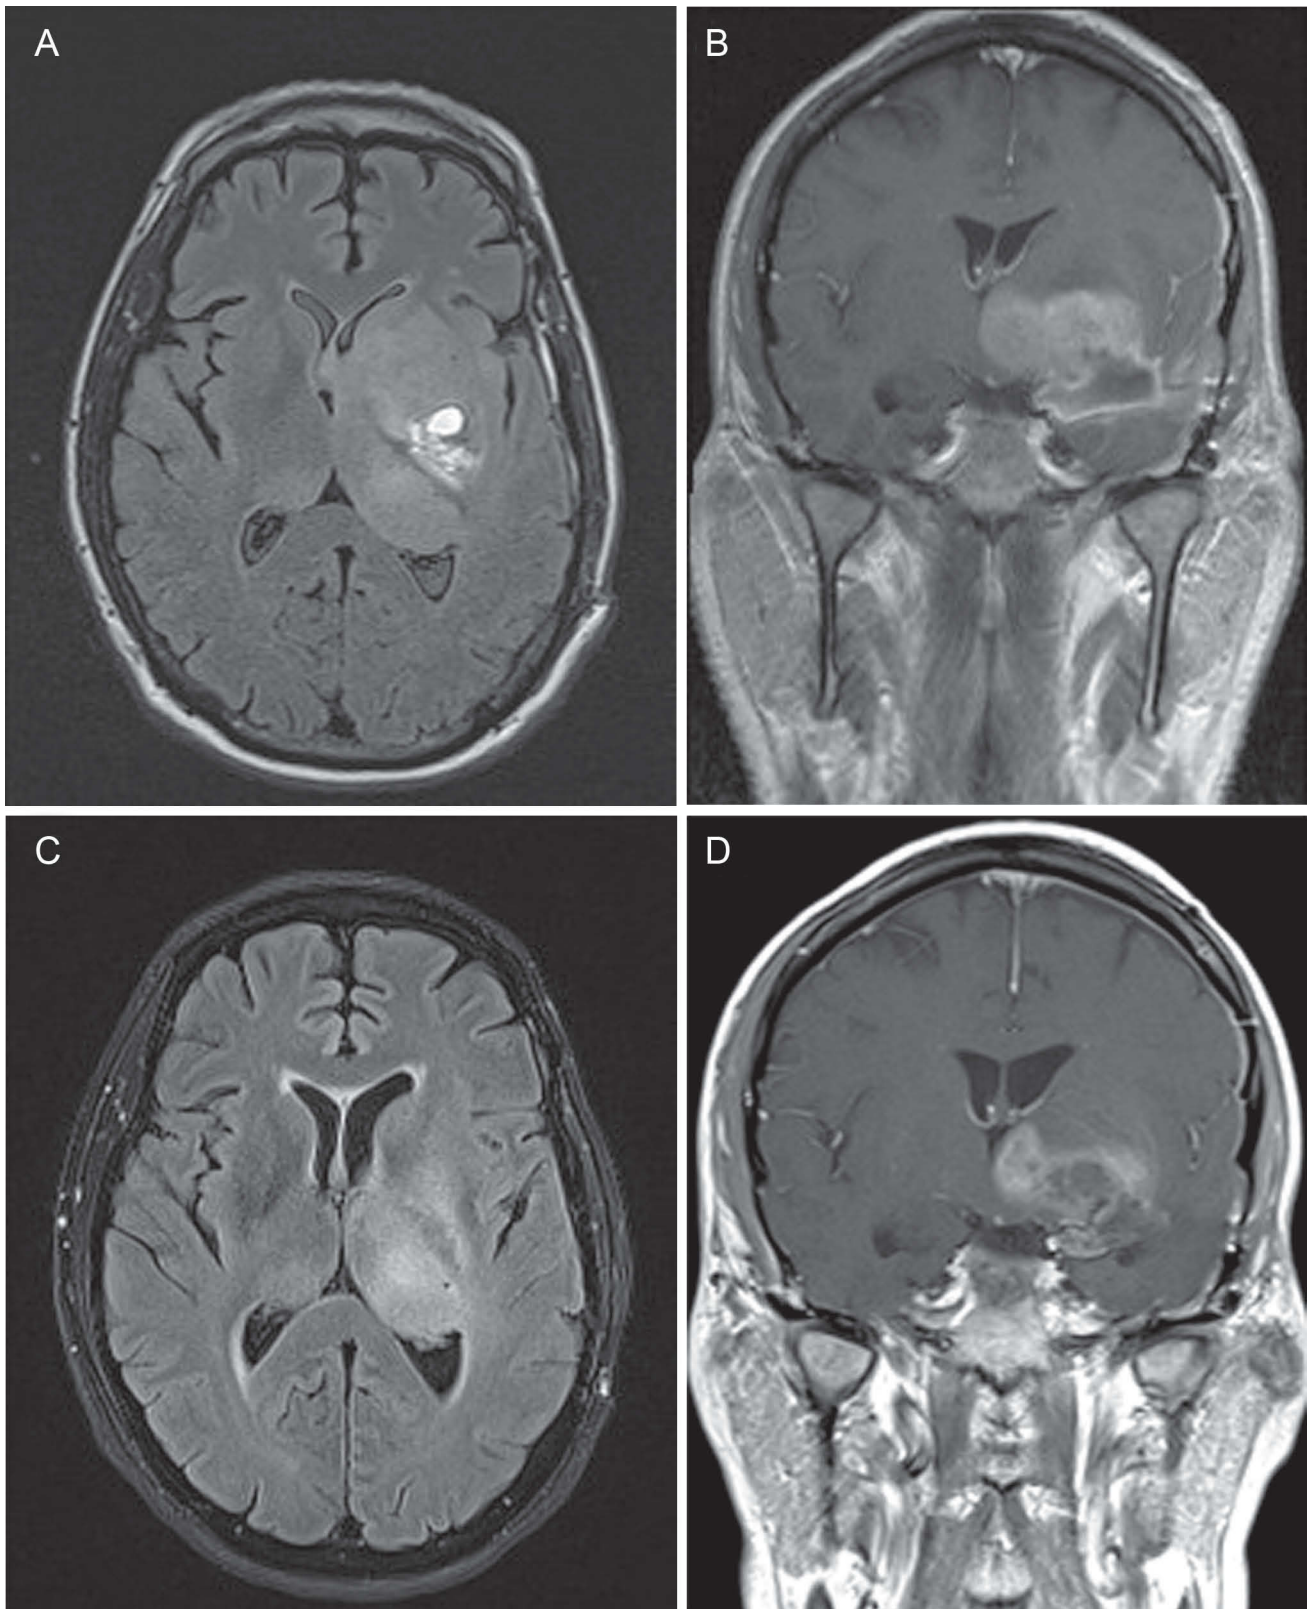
Magnetic resonance images of patient 1. Images A and B correspond to FLAIR and T1 gadolinium-enhanced sequences in the phase when his symptoms worsened. Images C and D correspond to the same sequences after treatment with bevacizumab (one cycle). Note the reduction in the mass effect, as well as the size of contrast uptake in the tumour. Furthermore, it is possible to observe a re-expansion of the ventricles to normal size.
